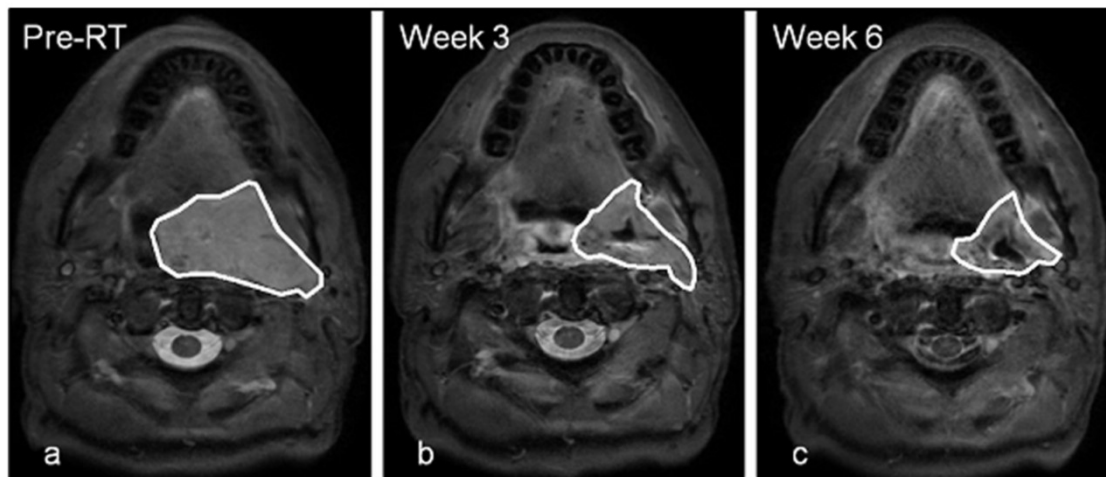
GTV delineations in patient 6 on MRI pre-treatment (a), in week 3 of treatment (b) and in week 6 of treatment (c).
